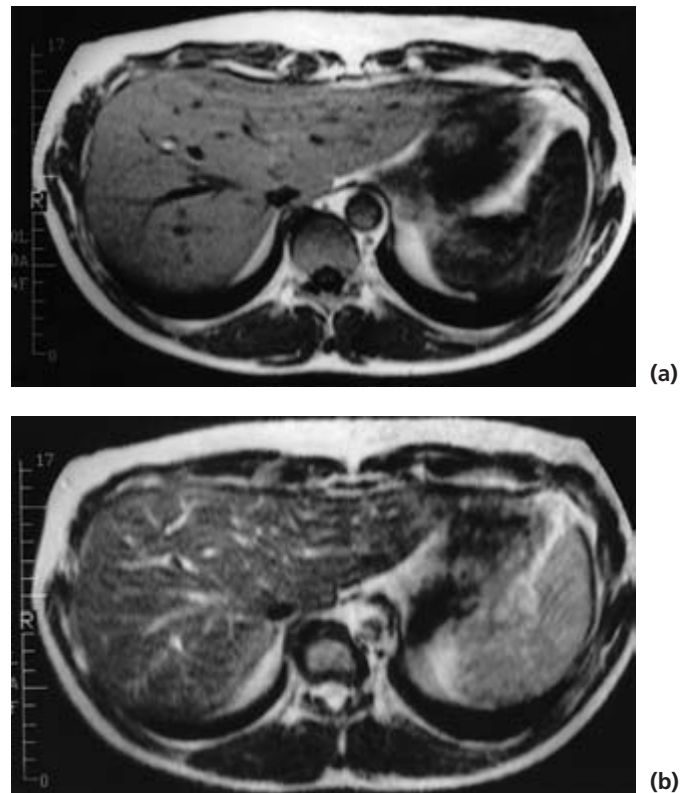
MRI scan in a normal adult volunteer. (a) T_1 -weighted scan (spin-echo 300/12). (b) T_2 -weighted scan (spin-echo 1500/80). Note that in the T_2 -weighted scan the spinal canal contents are bright (white) as are the blood vessels in the homogeneous liver (left).
